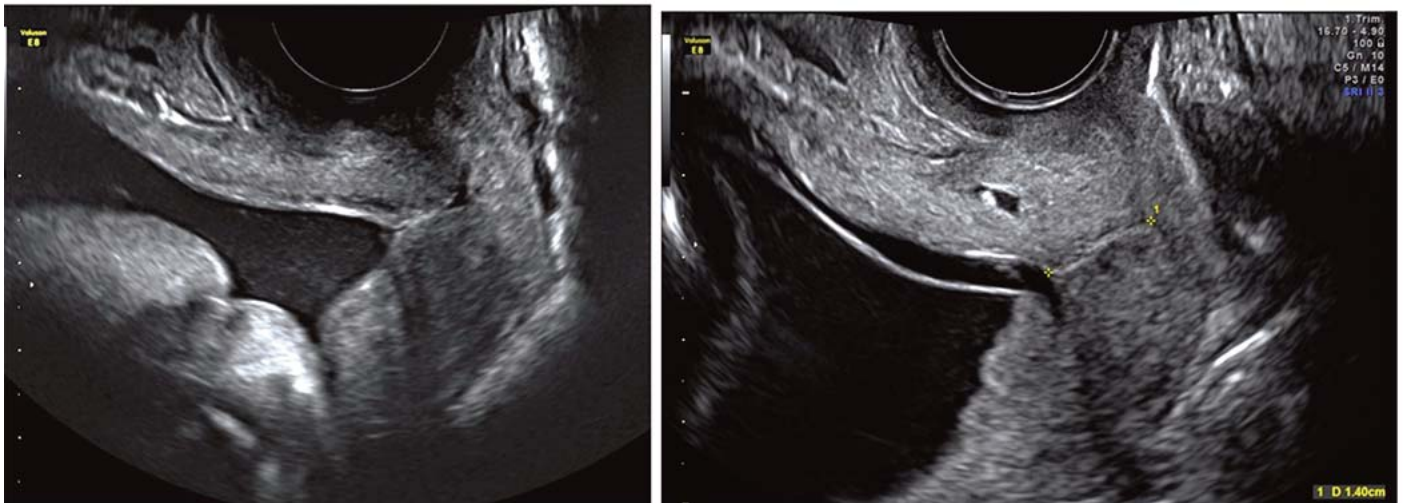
The 'V' shaped funneling of the short cervix by transvaginal ultrasound is shown in 2a. The amniotic sludge is depicted as a 'white asterisk' in 2b.
